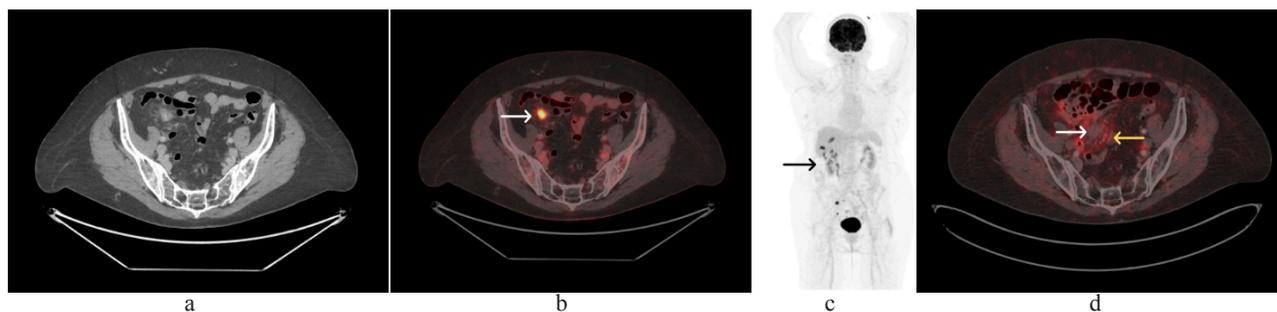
CT and fused ^{18}F -FDG PET/CT images of the pelvis (1a-b), maximal intensity projection (MIP, 1c) showing and intense ^{18}F -FDG- avid cartwheel lesion in the right abdominal fossa (black arrow) and fused ^{68}Ga -DOTANOC PET/CT image (1d) showing no SSR expression in the central mass (white arrow) and faint uptake in the surrounding desmoplastic reaction (yellow arrow).
